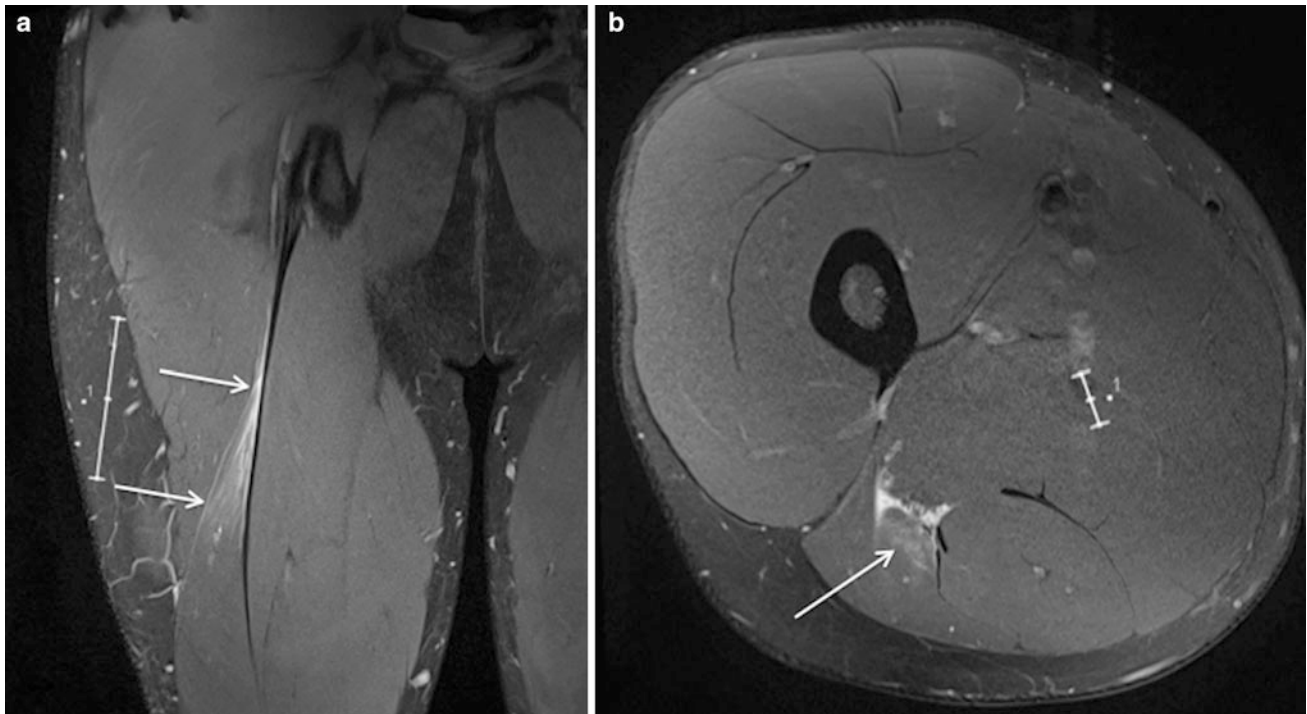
Coronal (a) and axial (b) proton density weighted MR images with fat saturation in an Australian Rules football player with grade 1 muscle strain injury centred on the proximal muscle-tendon junction of the long head biceps of femoris, manifest as mild feathery
